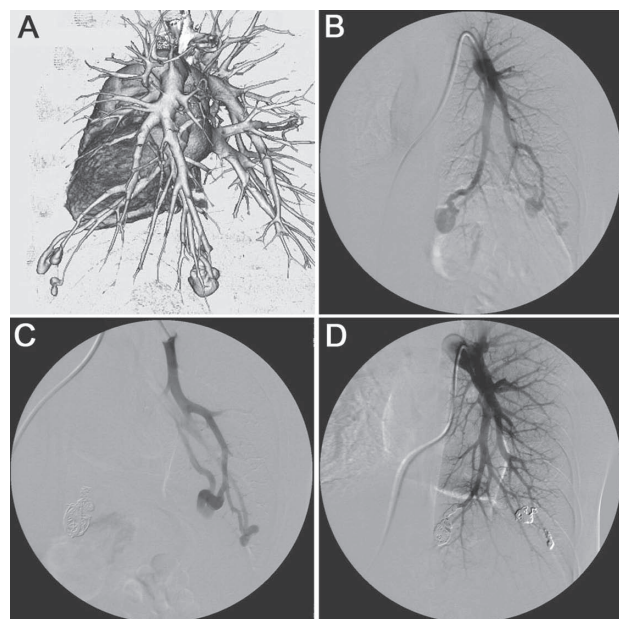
Embolization of a PAVM with a small, tortuous feeding artery in a 37-year-old man. A, B. Three PAMVs were confirmed with 3D CT and left pulmonary angiography. B. Feeding arteries were small and tortuous on selective angiography of the left A10. C. We successfully inserted a 2.5-Fr microcatheter into the venous sac and embolized the venous sac and feeding arteries.
